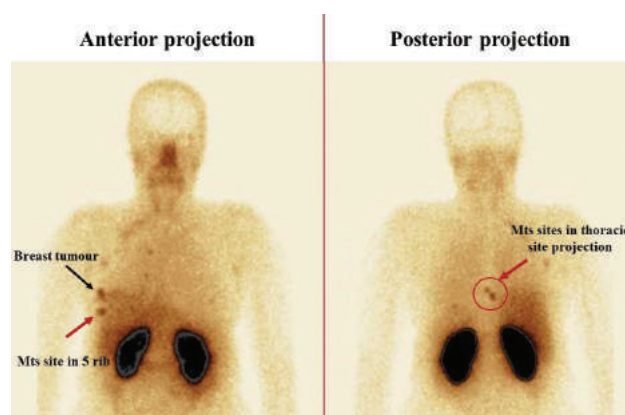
Planar scintigraphy of the HER2-positive breast cancer patient 2 hours after the  $^{99m}\text{Tc}$ -ADAPT6 injection (anterior and posterior projection): visualization of pathologic accumulation in the primary breast tumor projection (indicated by the black arrow); metastatic sites projected at the 5<sup>th</sup> rib (right) and Th 8–9 (indicated by the red arrow)
